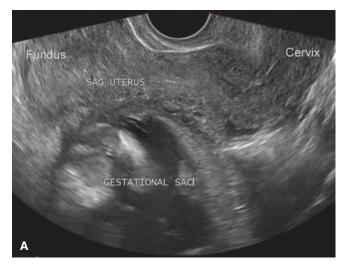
A. Sagittal transvaginal sonogram shows a gestational sac surrounded by myometrium. The gestational sac is not contiguous with the endocervical canal or with the main horn's endometrium. B. Here, two Pean clamps are placed across the vascular tissue bridge that separates the rudimentary horn (*above*) from the main uterine horn (*below*). (Reproduced with permission from Dr. Elaine L. Duryea.)
